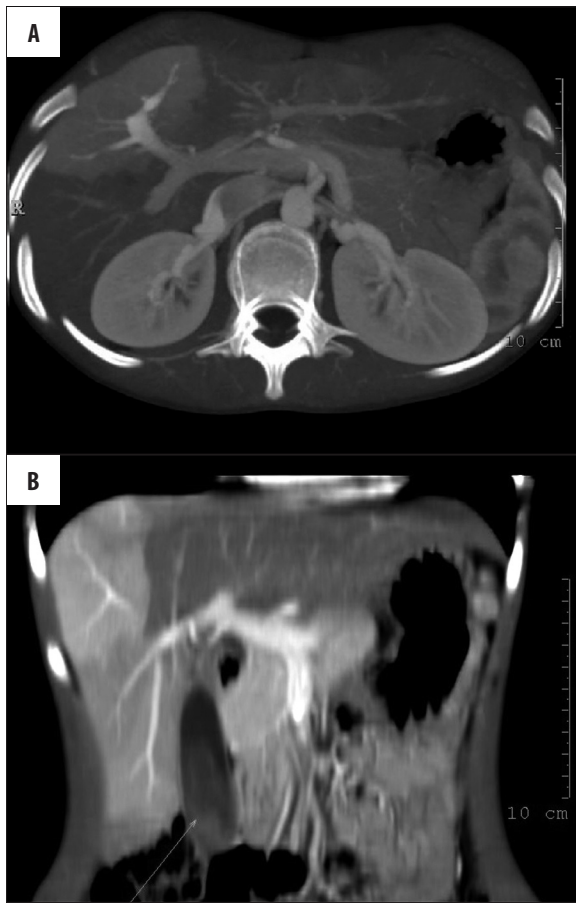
(A) In the late venous phase, the portal vein with intrahepatic flow is seen. Significant extravasation of the contrast agent from the middle portion of the right hepatic artery to one of the branches of the portal vein was found. During the examination the presence of contrast agent in the biliary ducts was observed which confirmed the existence of the arterio-biliary fistula with characteristic peripheral wedge-shaped hepatic parenchymal enhancement. (B) Coronal CT C + MPR reconstruction visualizes transient hepatic parenchymal enhancement (THPE). Triangular hyperattenuating area in hepatic arterial phase (segments VI and VII) with normal appearance of the rest of the liver in the portal phase. The presence of blood/haematoma in the gallbladder was confirmed (arrow).
